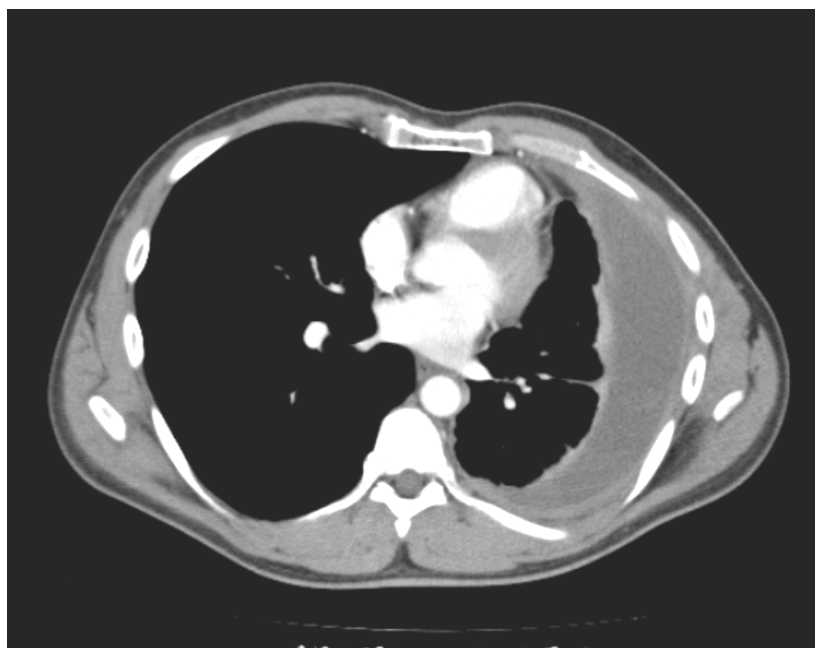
CT pulmonary angiography
